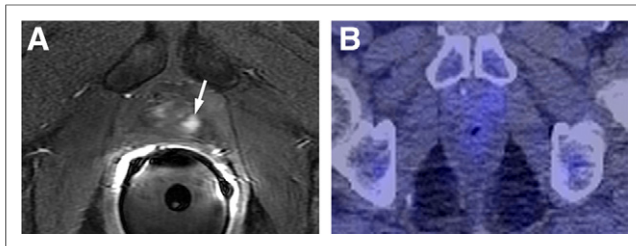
A 63-y-old patient with PSA level of 1.3 ng/mL, who underwent RP 10 y earlier and then received androgen-deprivation therapy. Results of discordant true-positive MR imaging and false-negative ¹¹C-choline PET/CT with a score for MR imaging of 5 and a score for ¹¹C-choline PET/CT of 1 for local recurrence are shown. (A) Hyper-enhancing nodule (6 mm) in prostatectomy bed to left of vesicourethral anastomosis on DCE MR imaging (arrow), which appeared slightly hyperintense on T2-weighted imaging (not shown). There was no corresponding restricted diffusion on apparent diffusion coefficient map (not shown). (B) ¹¹C-choline PET/CT at corresponding level shows no focal area of choline uptake.
